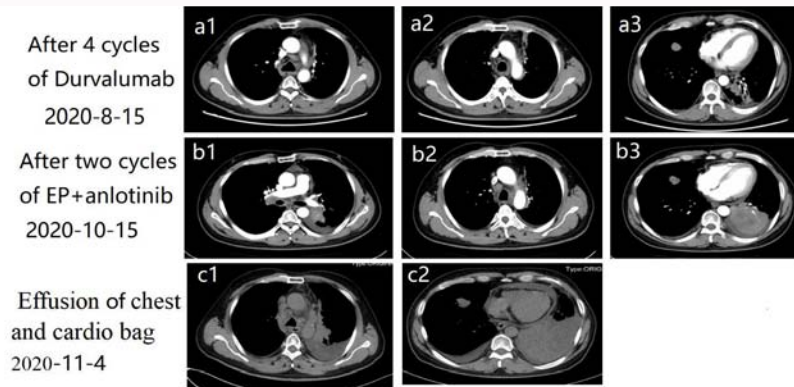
Serial abdominal CT scans show dynamic change of the follow-up treatment and the last period. a1, a2 after 4 cycles of immunotherapy with durvalumab, the mediastinal lymph nodes did not recur. a3 the primary tumor at the left lung recur and a new mass occur at the right low lung. b2 after two cycles of chemotherapy with EP (etoposide and cis-platinum) and anti-angiogenesis agent anlotinib, the mediastinal lymph nodes have no change compared before. b1, b3 the primary tumor progressed Fastly. c1, c2 at the last period, the pleural effusion and the pericardial effusion appeared.
